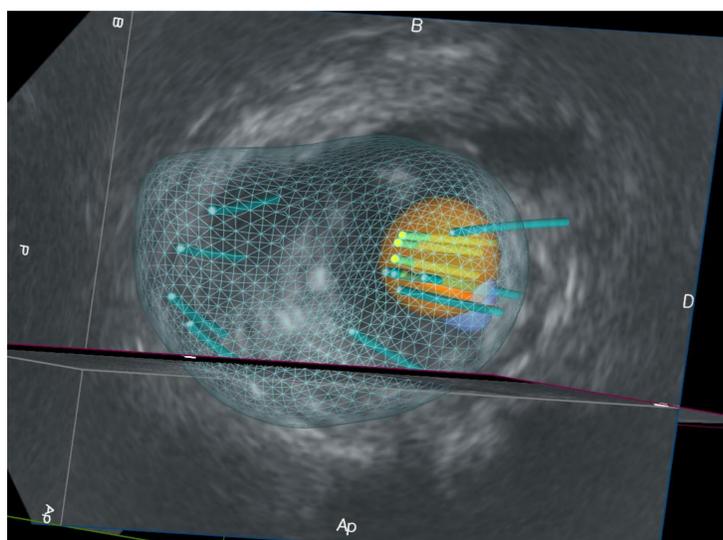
3-D reconstruction of the prostate as viewed by the operator during biopsy. The MRI target volume is now a 3-D region of interest (ROI- yellow) and the PSMA target volume is now a 3-D region of interest (ROI- blue) for a targeted biopsy. None of the old biopsies reach the suspect area at pet psma (blue zone) while they are within the suspect zone on the MRI (yellow zone)
